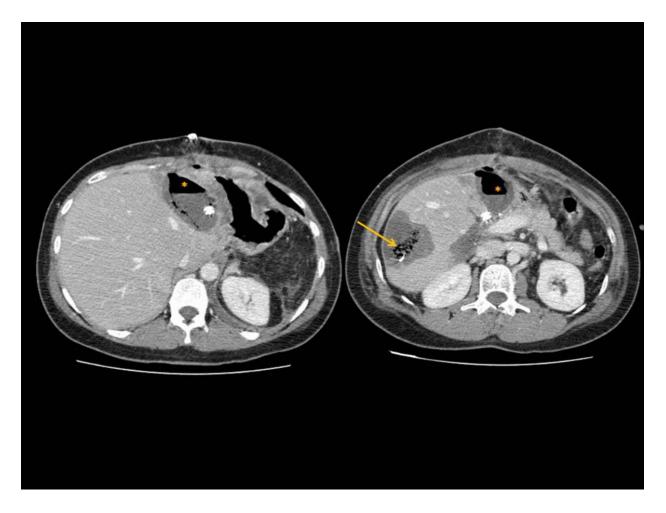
CT scan shows two hypodense areas with gas bubbles in the liver, both represent haemostatic material. However, one should consider the possibility of the more anterior area (*) representing a material overinfection, since there is an air-fluid level.
